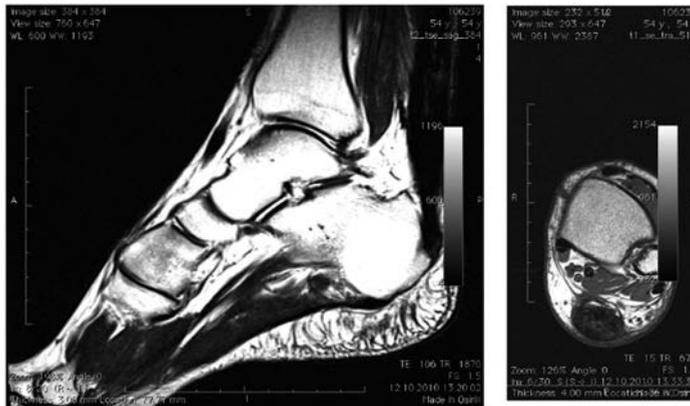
& 6 MRI images showing an repaired Achilles tendon 6 months postoperative
